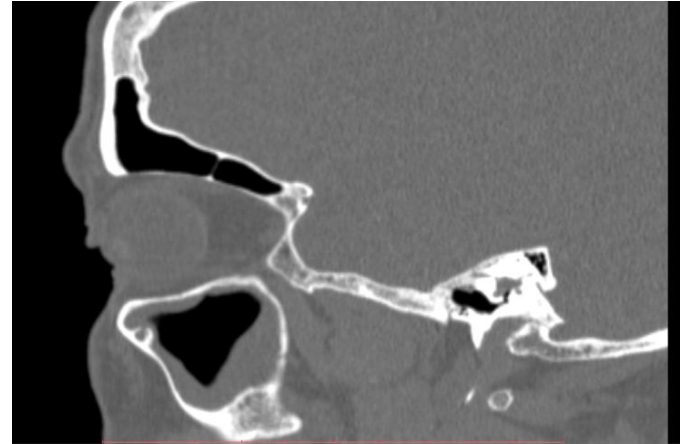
Sagittal reformatted CT of the left antrum showing mucosal thickening.
